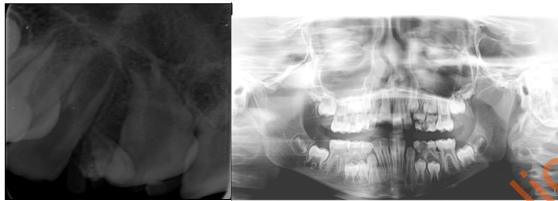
Periapical radiograph and OPG showing multiple calcified masses in anterior maxilla.
